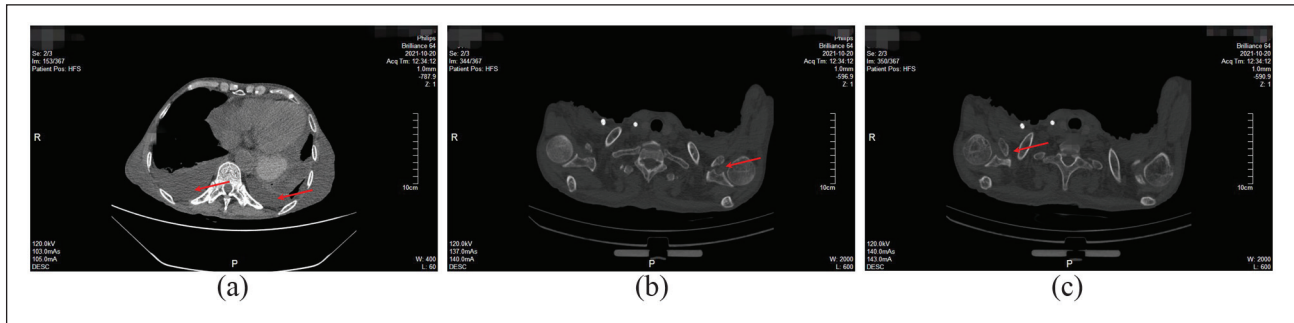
CT scan on 20 October 2021, indicating bilateral pleural effusion (a) and bilateral coracoid process fracture. The fracture did not heal, and sclerosis was present at the broken ends without bone destruction (b and c red arrows).
